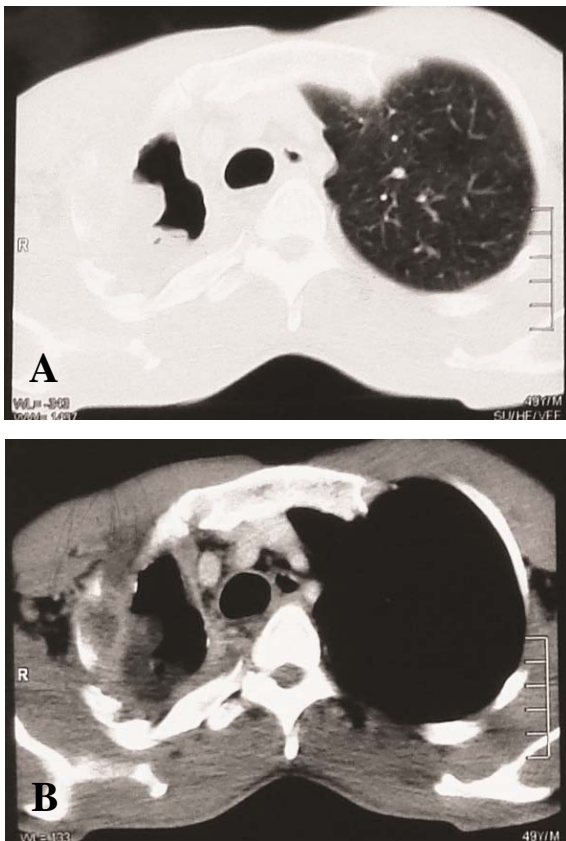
(A, B). Chest CT of the Patient in two different views.
